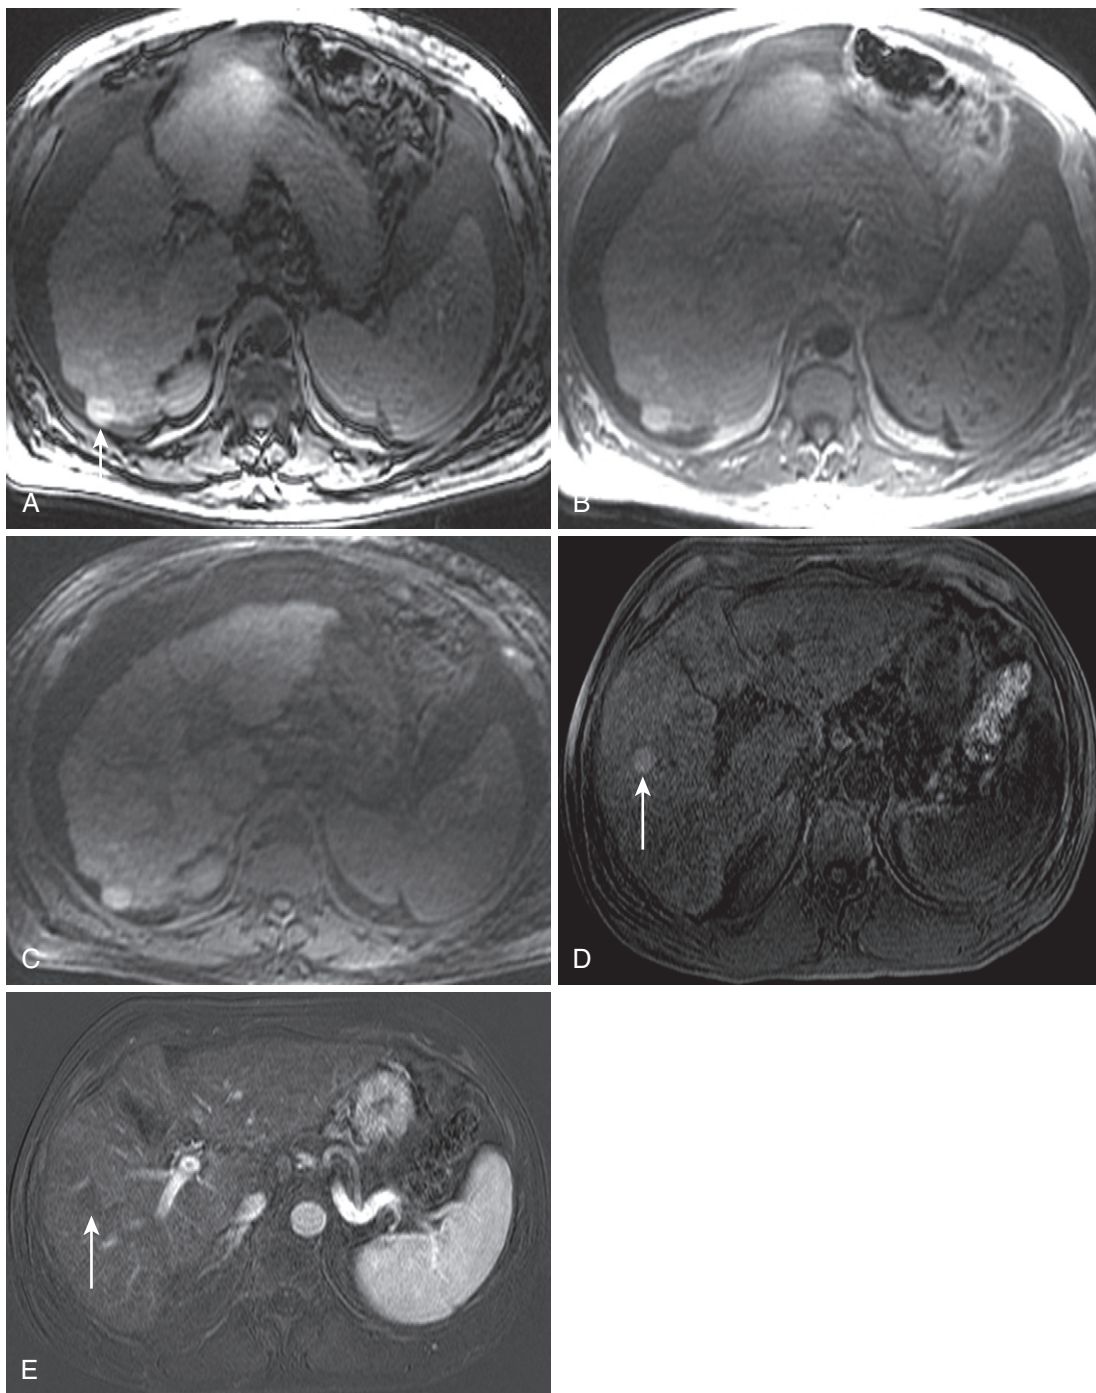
Dysplastic nodule. The opposed phase (A) and in-phase (B) images reveal a hyperintense nodular lesion (*arrow* in A) at the periphery of the posterior segment in a diffusely nodular, cirrhotic liver. C, The fat-saturated T1-weighted unenhanced image excludes T1 hyperintense fat. The T1-weighted fat-saturated image (D) in a different patient shows a similar hyperintense lesion (*arrow* in D and E) with lack of enhancement confirmed on the subtracted arterial phase image (E).
